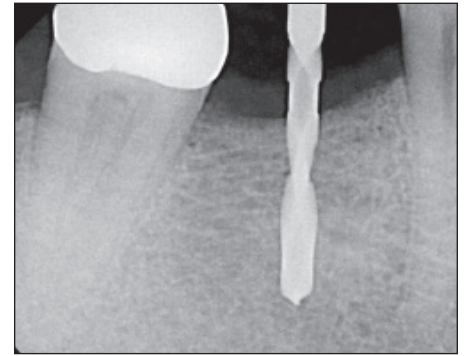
A 2.2mm diameter twist drill is used to establish depth. The intention is to determine a final depth no further than the apices of the adjacent root structures. The notches on the 2.2mm twist drill are marked 7mm, 9mm, 11mm, 13mm and 15mm. This digital radiograph indicates that the drill is 11mm at the crest of the ridge at the depth of the adjacent root apices
